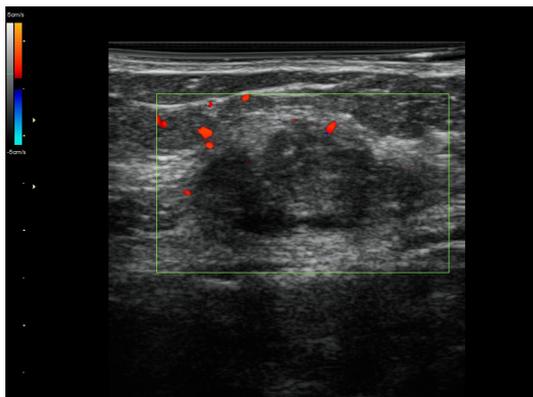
Color Doppler US image shows peripheral flow within the mass.
